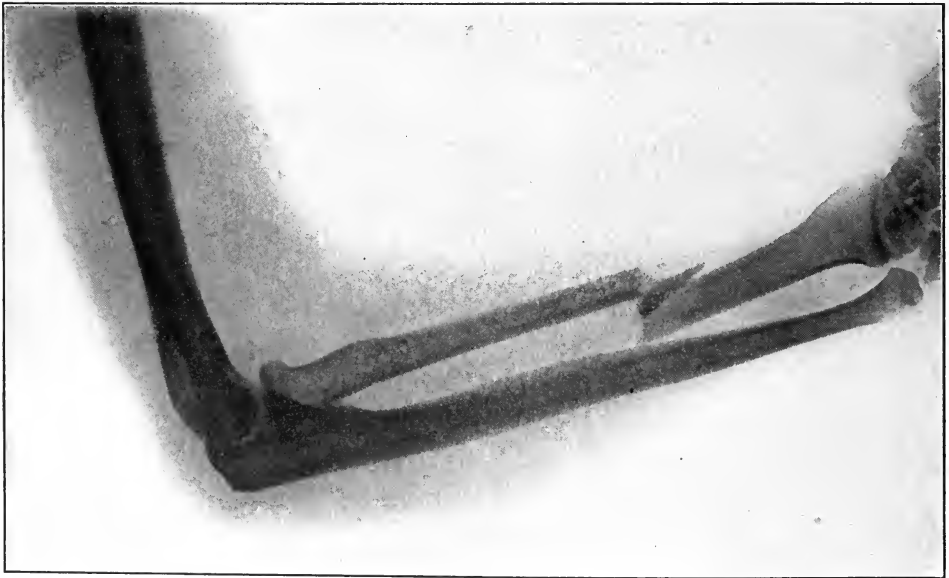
FRACTURE OF THE SHAFT OF THE RADIUS WITH SEPARATION OF A SMALL WEDGE-SHAPED FRAGMENT. (Case of Dr. Howard D. Collins, X-ray by the author.)
